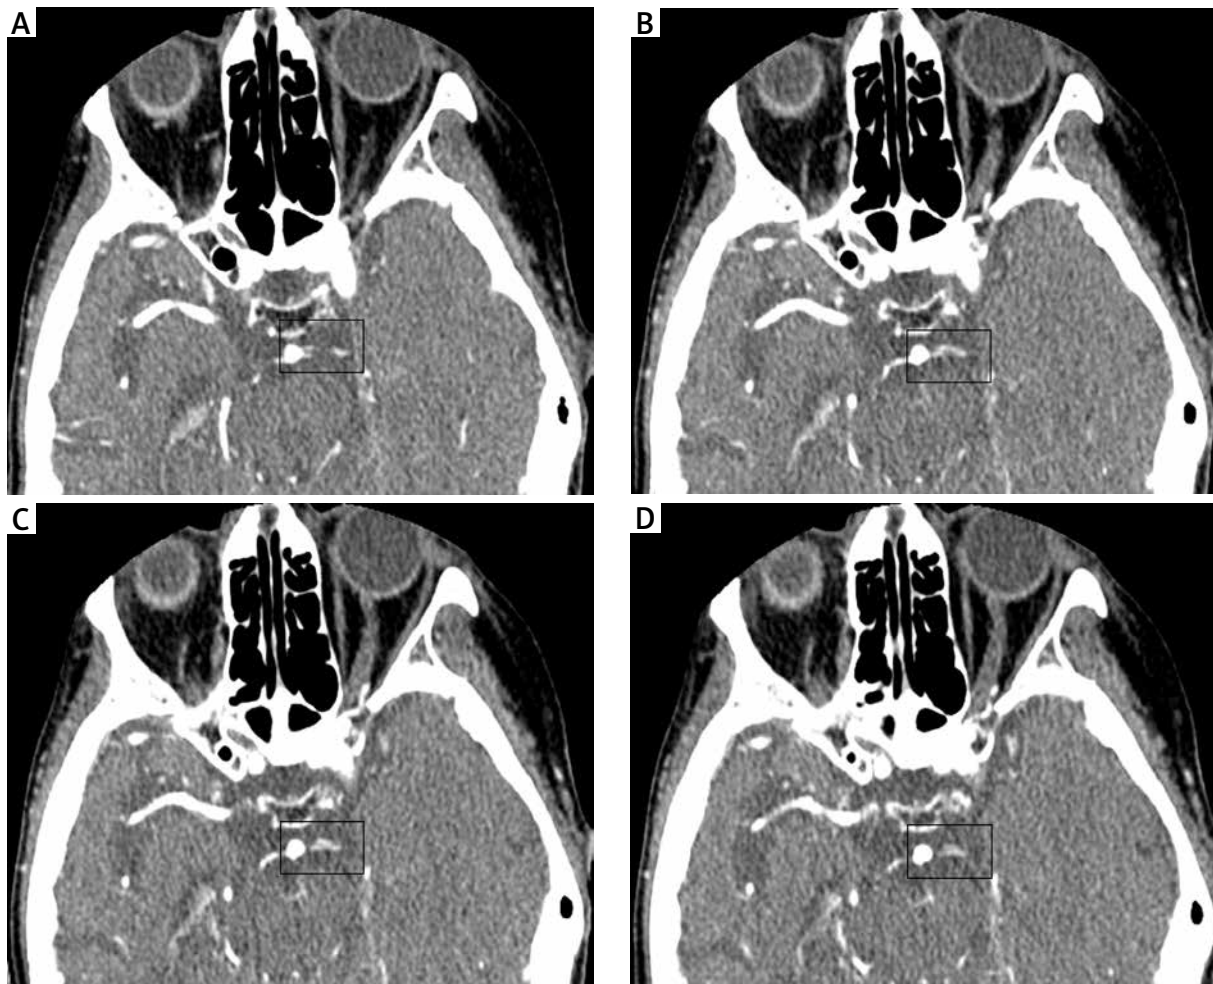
Computed tomography angiography on the 46th day showing the two components of the superior cerebellar artery arising separately from the vertebral artery and converging after brief courses into a single vessel.
